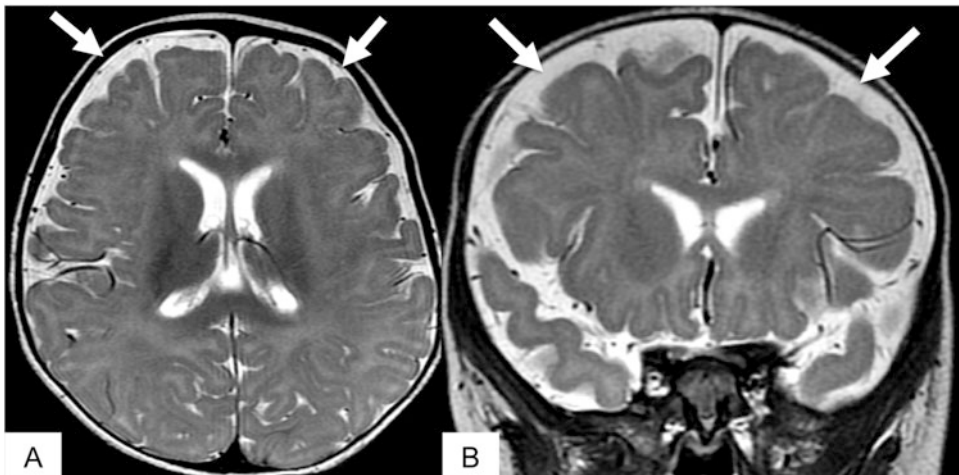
Benign enlargement of the subarachnoid space in infancy (BESSI). Axial (a) and coronal (b) T2W images on this newborn's MRI demonstrate enlarged bifrontal extra-axial CSF spaces. These are differentiated
